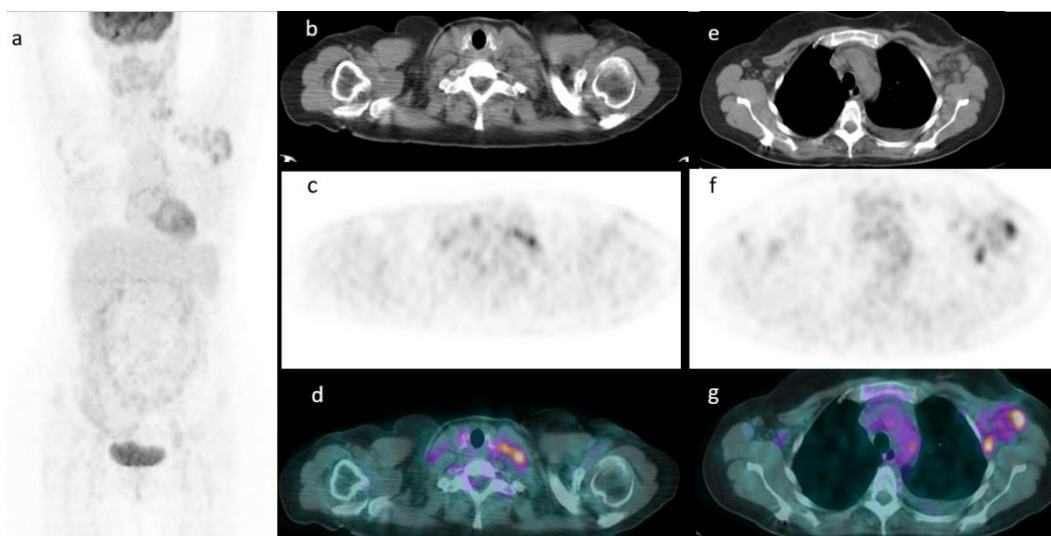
An example of a patients with FDG-avid laterocervical and axillary nodes at maximum intensity projection (MIP) (a). Axial CT (b), PET (c), and PET/CT fused images (d) confirming the presence of lymph nodes in left-side neck and in the left axilla (e–g).
